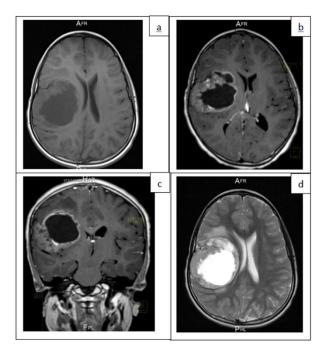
Preoperative MRI. (a) T1-weighted axial section showing a voluminous mixed (cystic and fleshy) extra ventricular intraparenchymal parietotemporal mass, well-limited, perilesional edema, mass effect on lateral ventricles and medial line deviation. On T1 sequences injected in axial (b) and coronal section (c) there is a homogeneous contrast taking at the level of the fleshy portion. T2 -weighted sequence (d) shows a cystic appearance of the lesion part.
